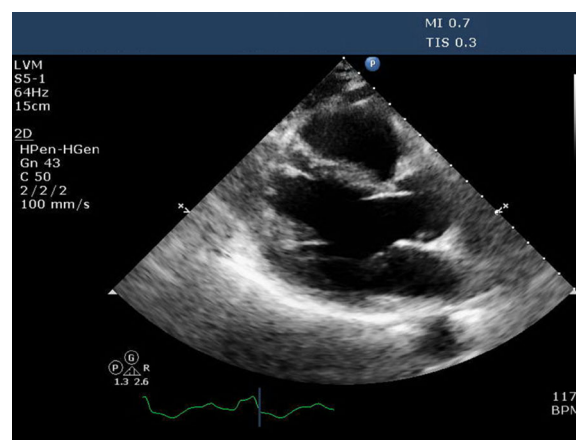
Transesophageal echocardiogram (TEE) after surgery revealing dilation of the inferior vena cava (IVC), right atrium and right ventricle and a mass (approximately 2×1.5 cm) attached to the base of the right ventricular wall just below the insertion of the anterior tricuspid leaflet
